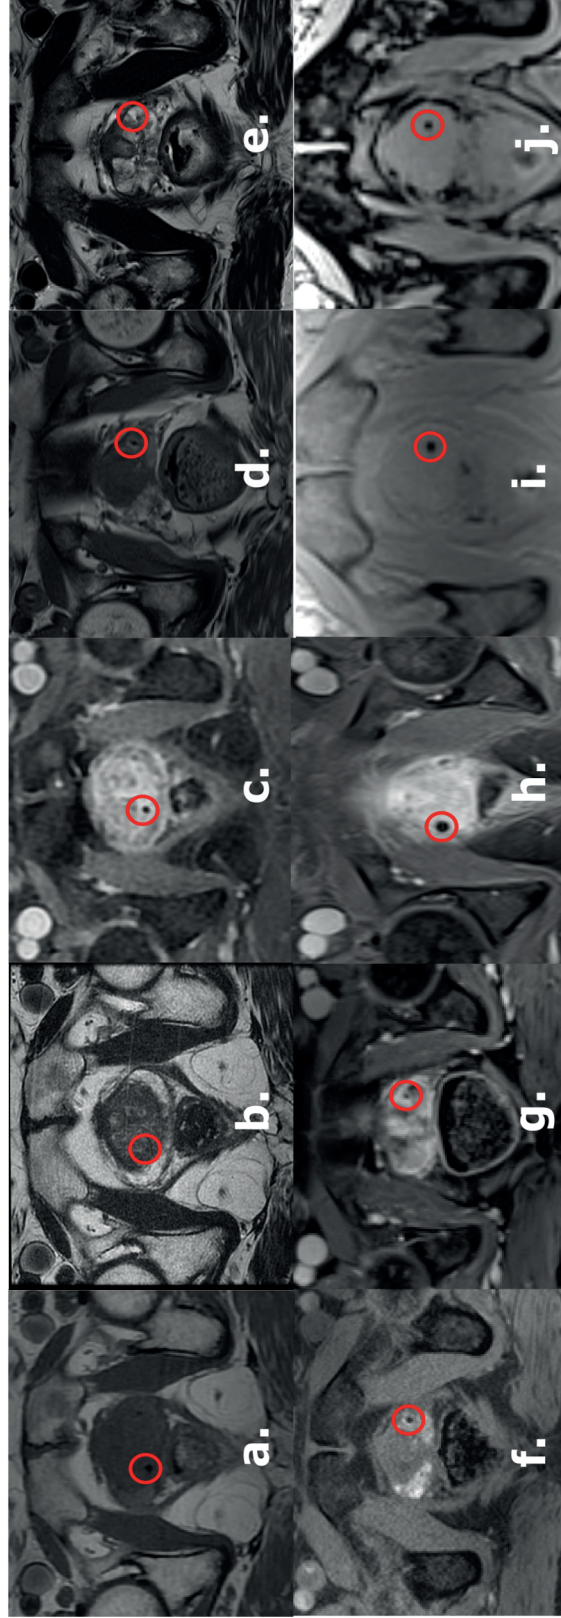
Prostate MRI images of each pulse sequence with an implanted marker circled in red. Tested pulse sequences included (a) 1.5T T₁-FSE, (b) 1.5T T₂-FSE, (c) 1.5T T₁-LAVA, (d) 3.0T T₁-TSE, (e) 3.0T T₁-TSE, (f) 3.0T T₂-TSE, (g) 3.0T T₁-VIBE, (h) 3.0T T₁-VIBEcaipi, (i) 3.0T T₁-VIBEe1 and (j) 3.0T T₁-VIBEe2.
